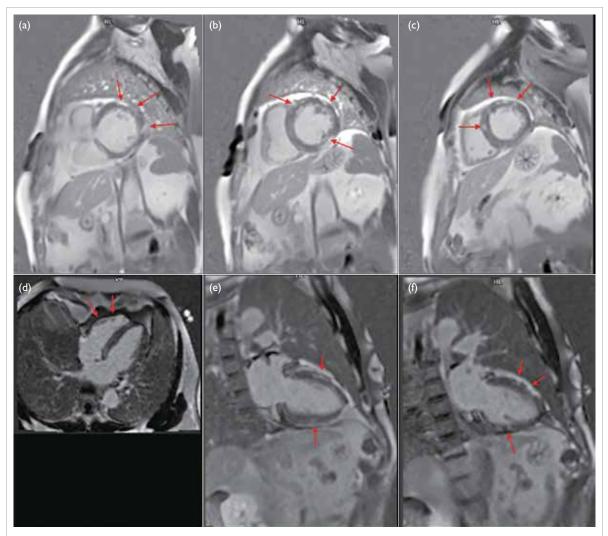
Multifocal patchy mid-wall and subepicardial late gadolinium enhancement at mid-ventricular anterior, anteroseptal and anterolateral walls, as well as basal to mid-ventricular inferior and inferolateral walls (arrows). (a-c) Short axis views of the left ventricle. (d) Apical four-chamber view of the left ventricle. (e, f) Apical two-chamber view of the left ventricle
